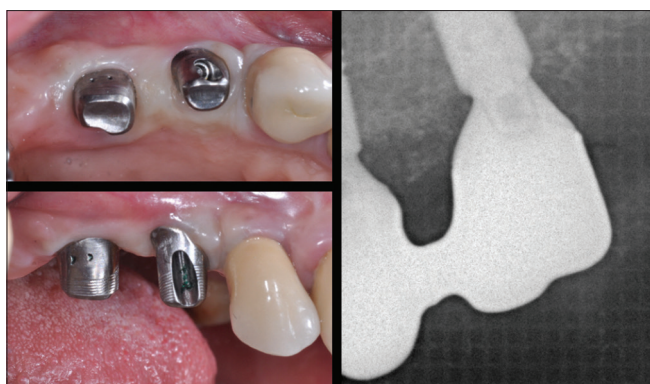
The abutments and the structures are checked clinically and radiographically.
